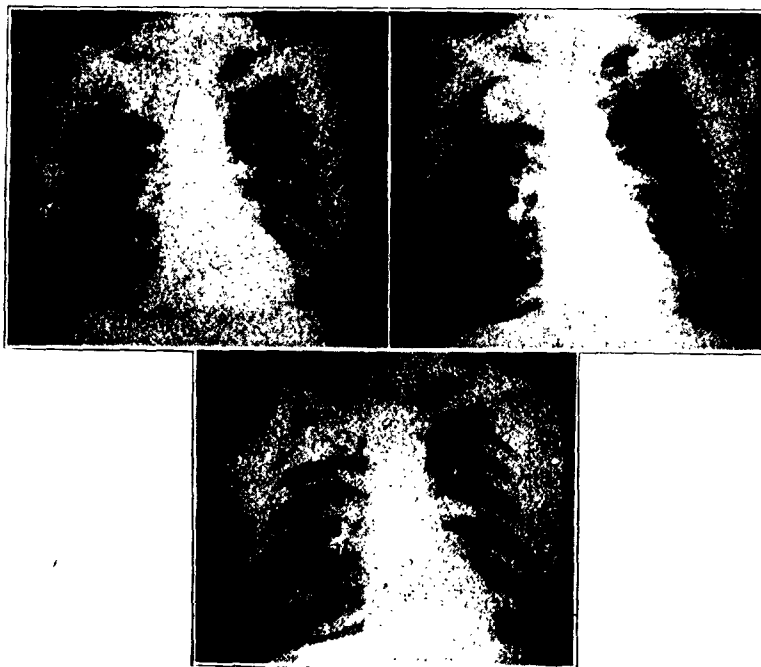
(case 3).—Serial roentgenograms taken in 1942 (A), 1944 (B) and 1946 (C) showing infection in the upper lobe of the right lung superimposed on an extensive nodular background. The infection has shown no change in more than two years.
